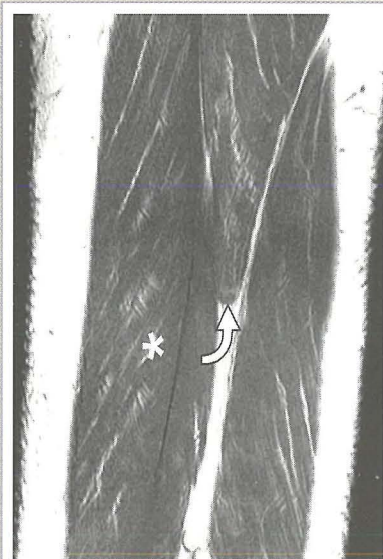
The patient presented with acute distal posterior knee pain during rehabilitation following ACL reconstruction. Coronal MR image shows avulsion of the semitendinosus tendon (arrow), with retraction of the muscle. The long head of the biceps femoris is located laterally (*), and the semimembranosus medially.
